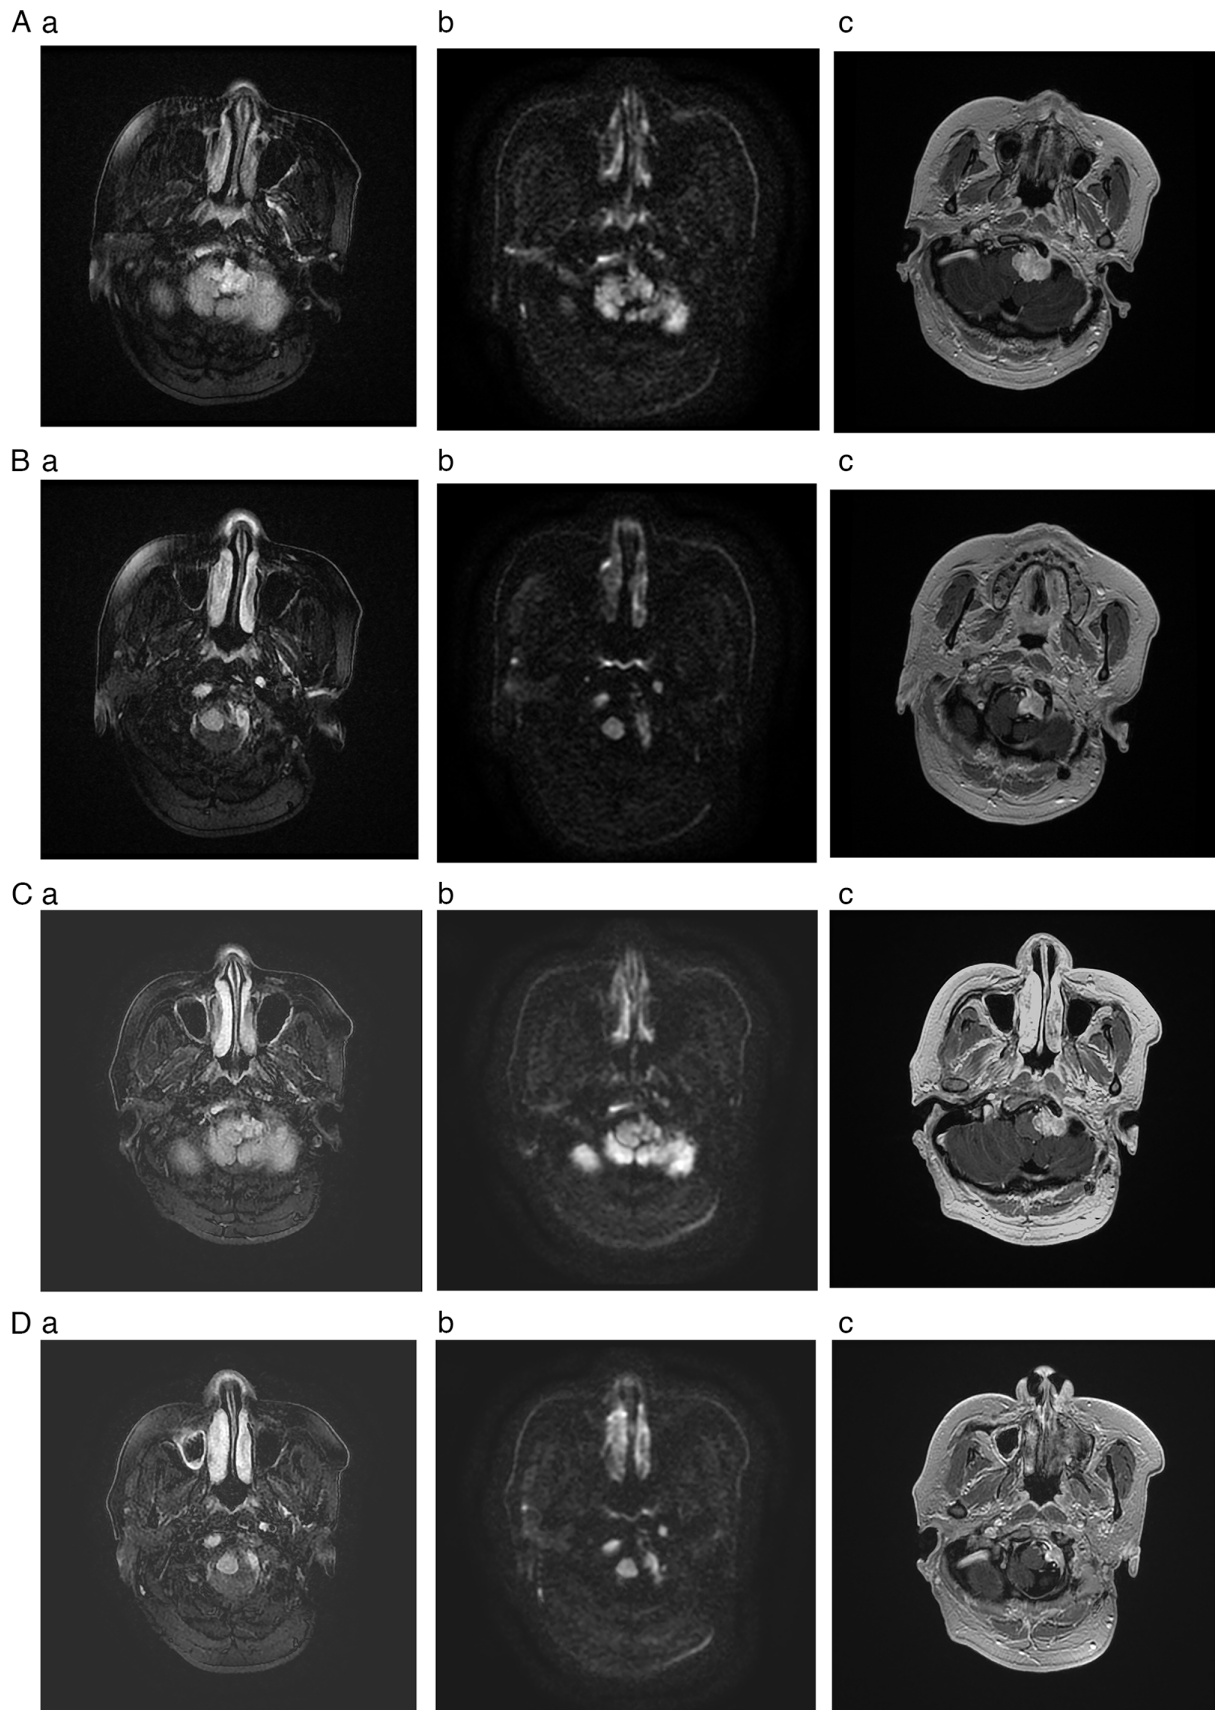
Magnetic resonance imaging study during follow-up. (A and B) Images obtained at 11 months post-treatment (April 2024). Images (A) and (B) represent different axial section levels. (C and D) Images obtained at 18 months post-treatment (December 2024). Images (C) and (D) represent different axial section levels. (A-a, B-a, C-a and D-a) T2-weighted fluid-attenuated inversion recovery sequences marked by a nodular, somewhat hyperintense signal involving the left jugular bulb region and the left lateral medulla oblongata. (A-b, B-b, C-b and D-b) DWI demonstrating isointense or now vaguely hypointense signaling in these areas. (A-c, B-c, C-c and D-c) T1-weighted imaging, again disclosing moderate contrast enhancement in a heterogeneous pattern at the aforementioned sites. Relative to pretreatment status in Fig. 3 (May 2023), follow-up views (A and B) at 11 months and (C and D) 18 months confirm significant tumor volume reduction and diminished DWI signal intensity, suggesting pronounced decline in tumor activity. DWI, diffusion-weighted imaging.
